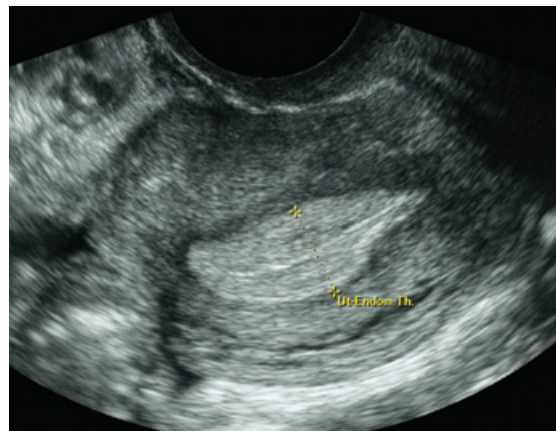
Ultrasound appearance of the endometrium in the secretory phase of the menstrual cycle. The increase in echogenicity is due to the increase in the number and tortuosity of the reflecting surfaces of vessels and glands within the endometrium.
